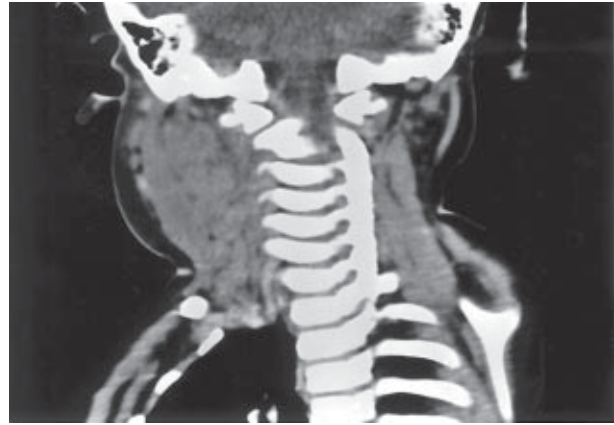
Computed tomography scan reveals massive lymphadenopathy over the right neck area.
